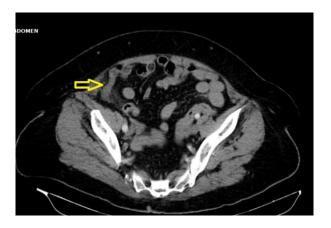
Abdominal CT showed are an increase in appendix diameter and appendicolitis
